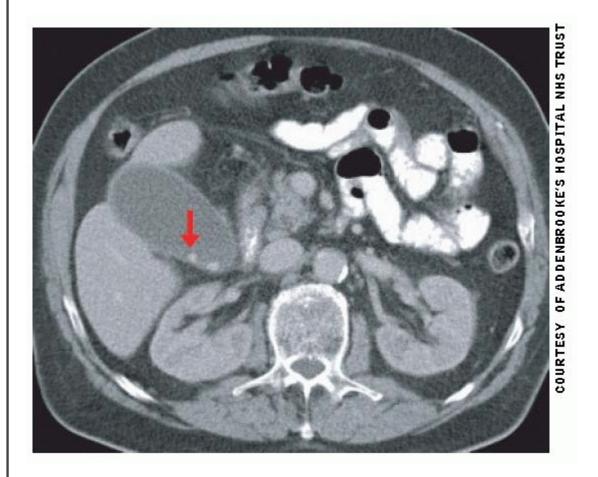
Axial CT of the abdomen post IV and oral contrast medium. The gallbladder contains gallstones (arrow). Oral contrast medium is seen within the small bowel but not the large bowel. Lateral to the vertebral column are the psoas muscles and the kidneys. Anterior to the vertebrae are the IVC and the aorta. Anterior to the IVC is the uncinate process of the pancreas.
